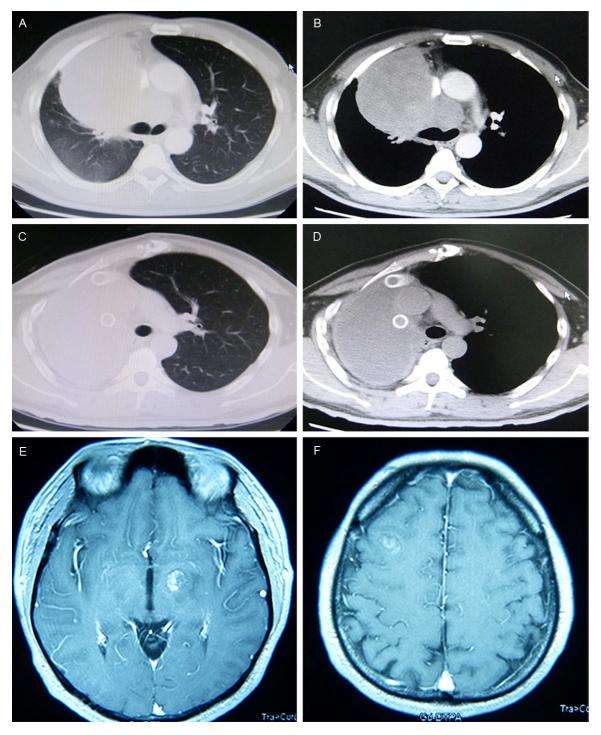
A, B. Pre-treatment CT showed a tumor of the right upper and media lobe with a diameter of 12 cm. C, D. post-operation CT. E, F Brain MRI showed multiple metastases after 2 cycles of chemotherapy.
